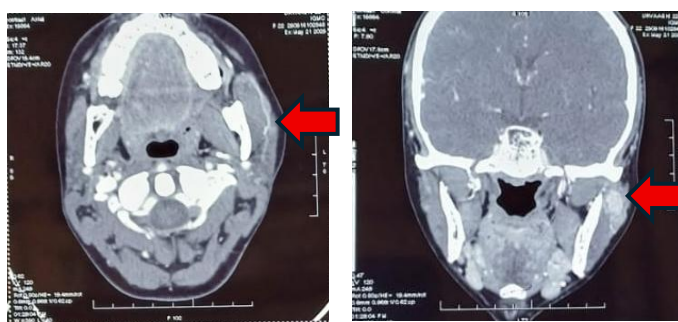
Contrast-enhanced computed tomography (CECT) image showing a heterogeneously enhancing soft tissue lesion in the left parotid–masseteric region, abutting the masseter muscle and extending beneath the superficial lobe of the parotid gland.
